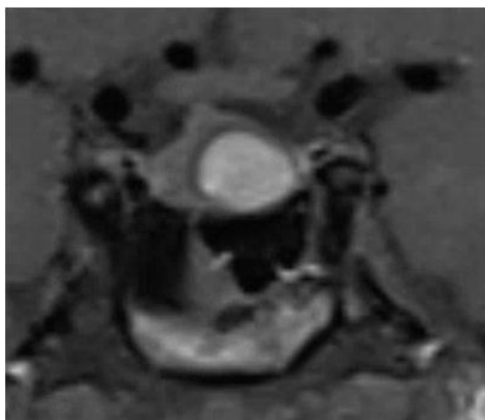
At diagnosis, coronal T1-weighted image showed a 1 cm hyperintense pituitary tumor.
